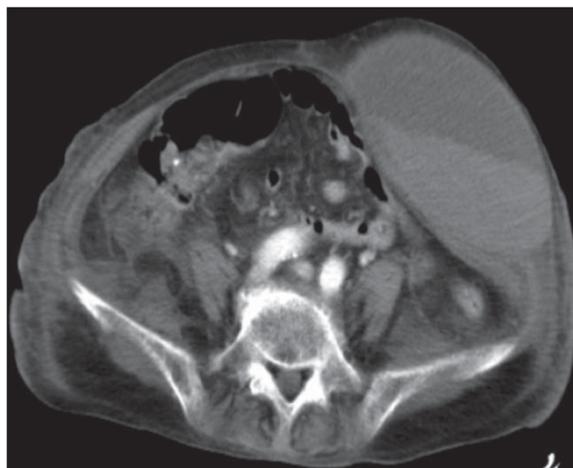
A lower abdominal CT scan revealed hematoma located in the rectus sheath.
